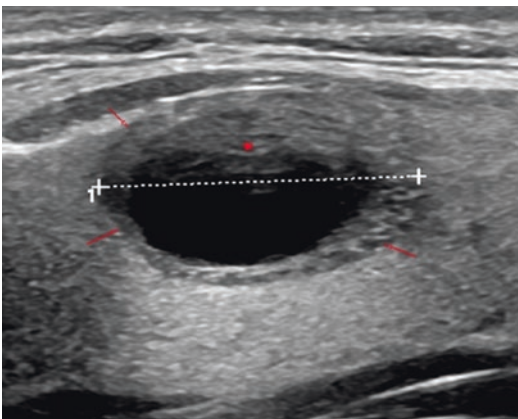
A predominantly cystic lesion with a concentric rim of solid tissue (small arrows) can safely be diagnosed as benign on ultrasound. Note the artifacts from reflections at surfaces from above tissue layers (asterisk) within the cyst and a brightening artifact dorsal to the cyst
